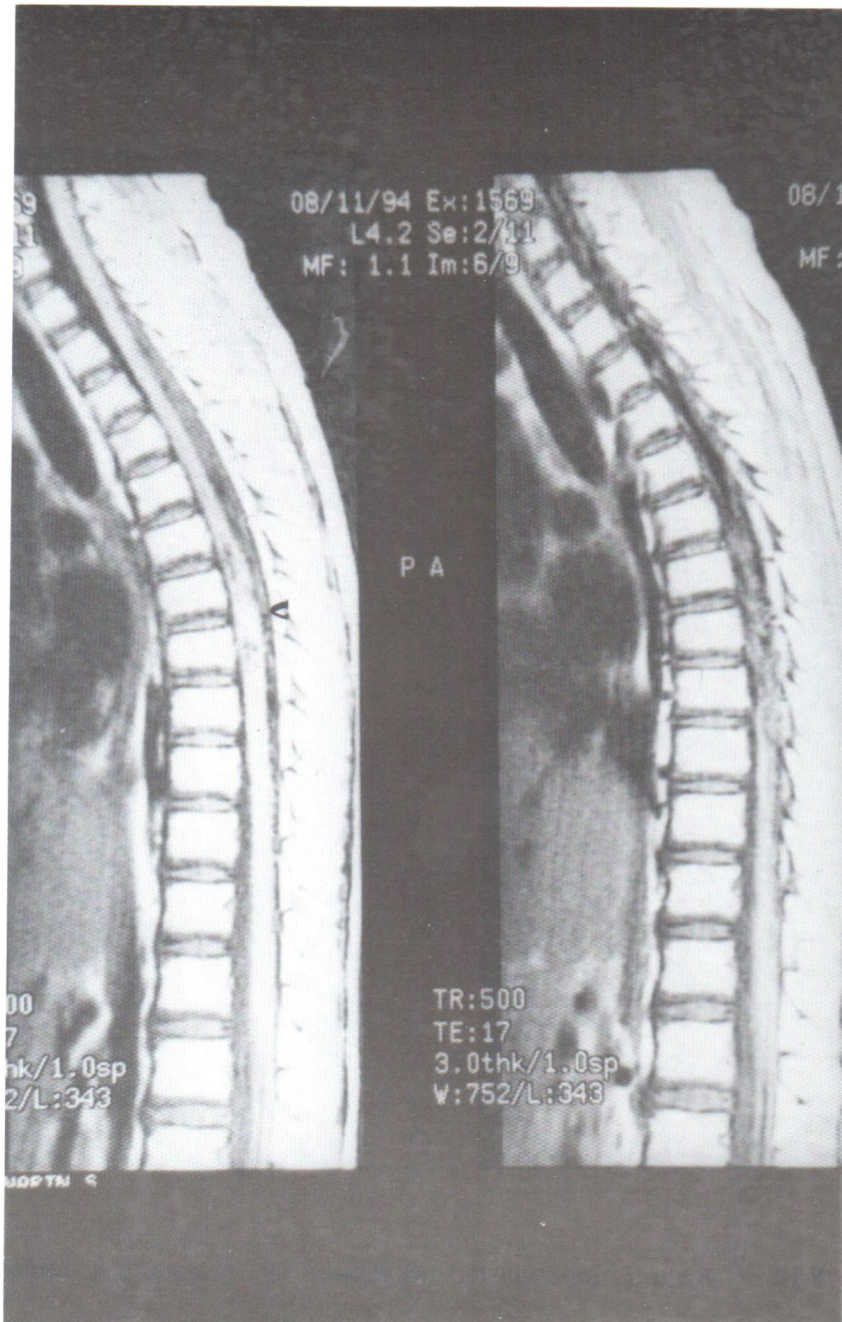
MRI sagittal T1W showed hemorrhage within the cord at level of T<sub>6-7</sub> (arrow) with dorsal tubular longitudinal flow void structures of draining veins.
